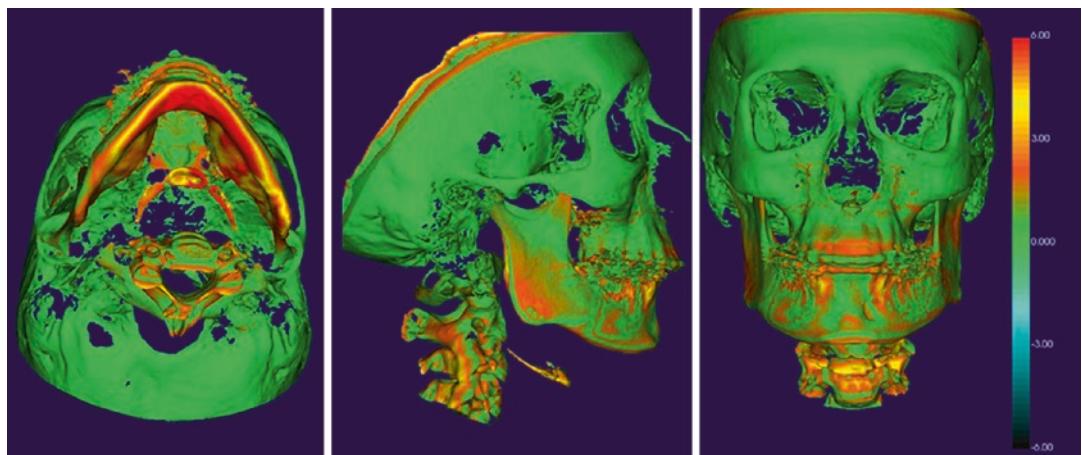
CBCT superimposition of an adult patient had an orthognathic surgery. 3D models color maps showing the surface distances between presurgical and 6-month
